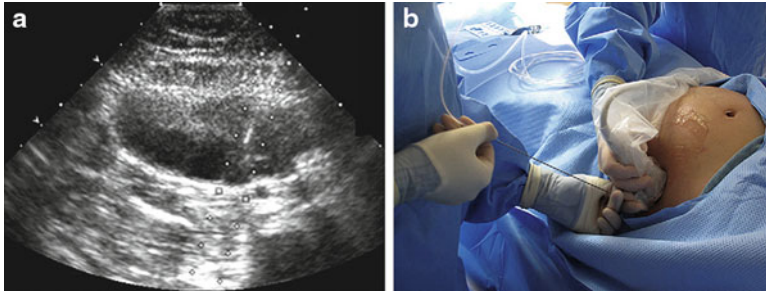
(a) Ultrasound image showing the use of the needle guide (*dotted lines*) during transabdominal oocyte retrieval. (b) Operative setup during transabdominal
